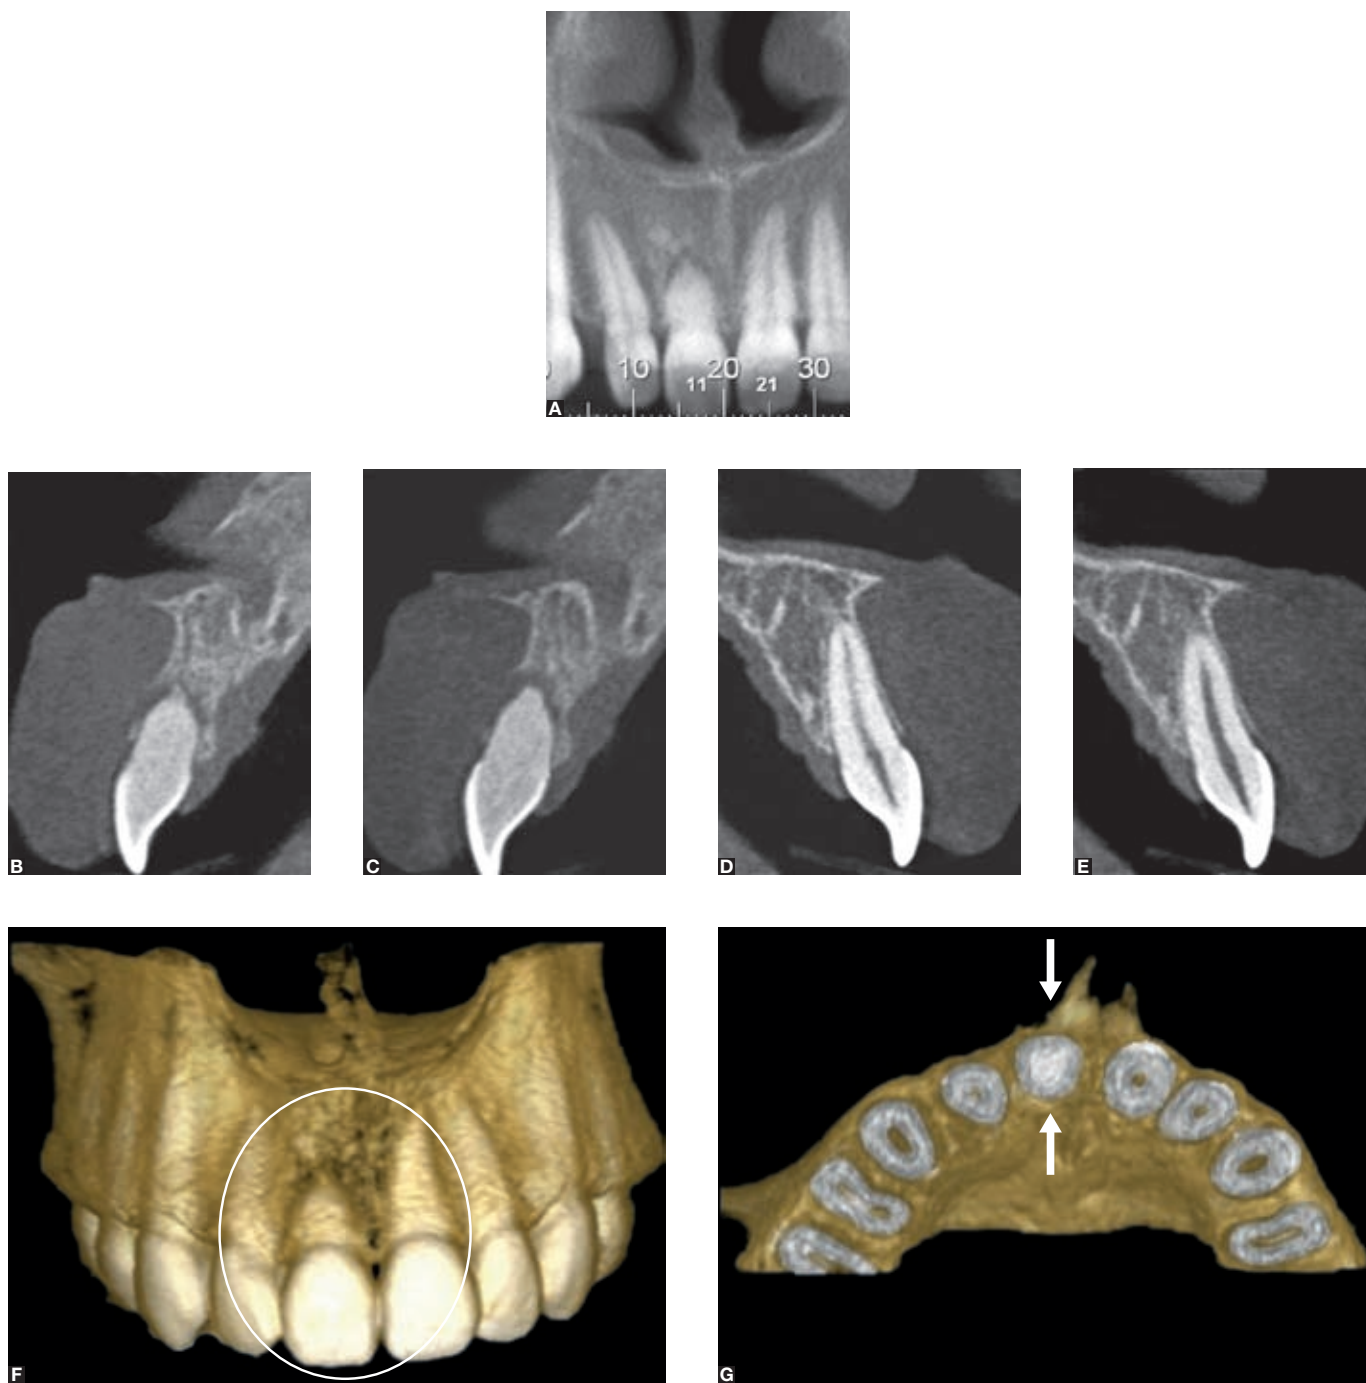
Dental trauma of incisor (11), which progressed into calcific metamorphosis of the pulp; CT scans show obliteration of pulp space and no definition of pulp margins (B and C) when compared with other central incisor (D and E). Three-dimensional reconstruction (F) shows that root is shorter (circle) and that there are separate apical fragments. Three-dimensional transverse views (G) show total obliteration of root canal by dysplastic dentin (arrows).
